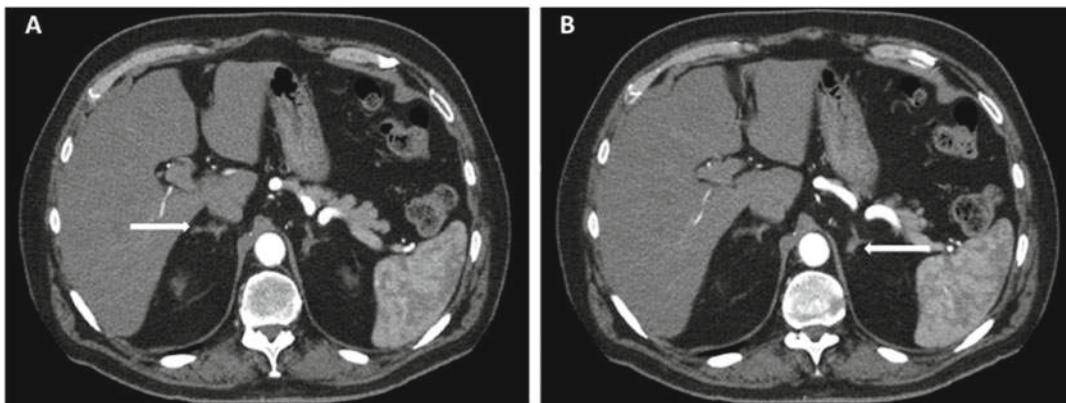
Computed tomography demonstrating multiple right (a) and left (b) microadenomas and a thickened limb on the left adrenal gland
